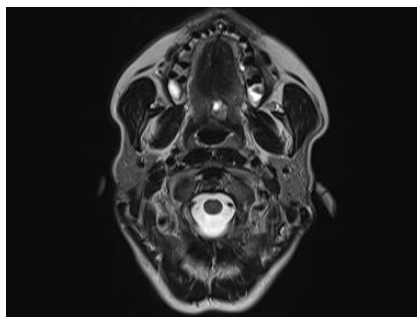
T2-weighted MRI in transversal plane showing the well demarcated, mixed hyperintense and hypointense lesion of the palate.
